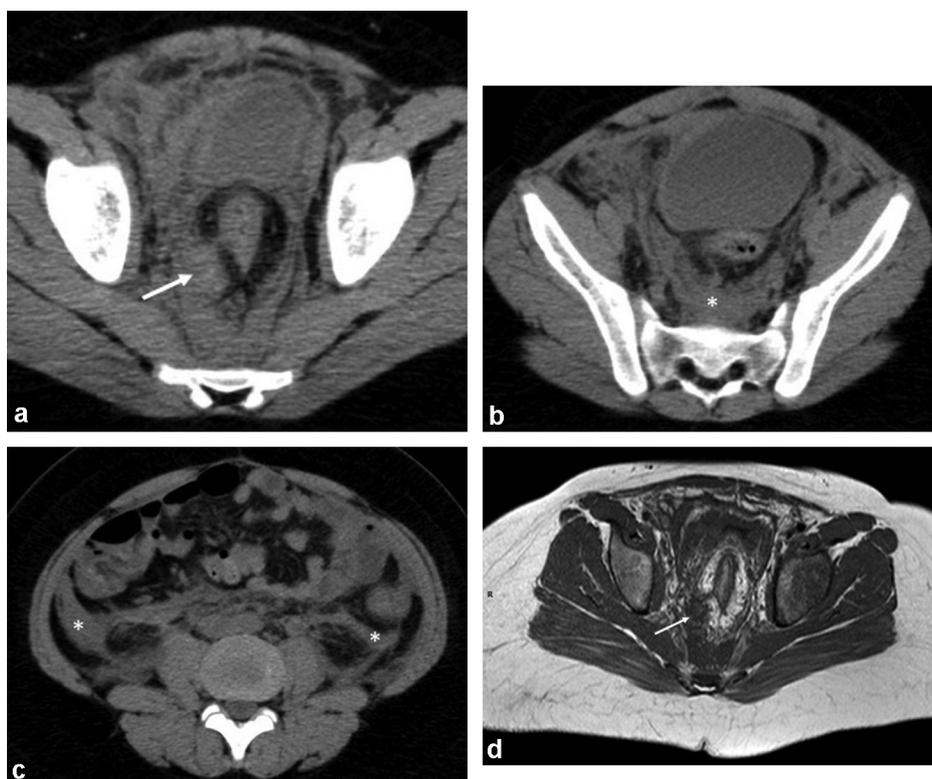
10-year-old boy with severe hemophilia A presenting with acute abdominal pain, pelvic tenderness and serum hemoglobin level of 6 g/dL 24 hours after rectal lavage for longstanding constipation. Unenhanced abdominal CT images (A–C) in the transverse plane at three different levels show rectal wall hematoma that ruptured into the mesorectum (arrow) and retroperitoneal and peritoneal spaces (asterisks). T2-weighted MR image of the rectum (D) in the transverse plane shows hypointense collection in the mesorectum (arrow). The very low signal intensity strongly suggests hematoma containing deoxyhemoglobin. Rectal endoscopy confirmed a 1-cm long submucosal rectal hematoma.
